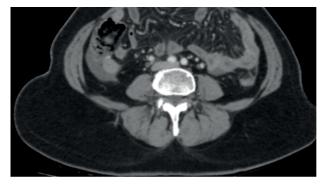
Axial view of computed tomography scan of abdomen post contrast enhancement, showing mass-like enlargement and enhacement of appendix. There is moderate ascites.
